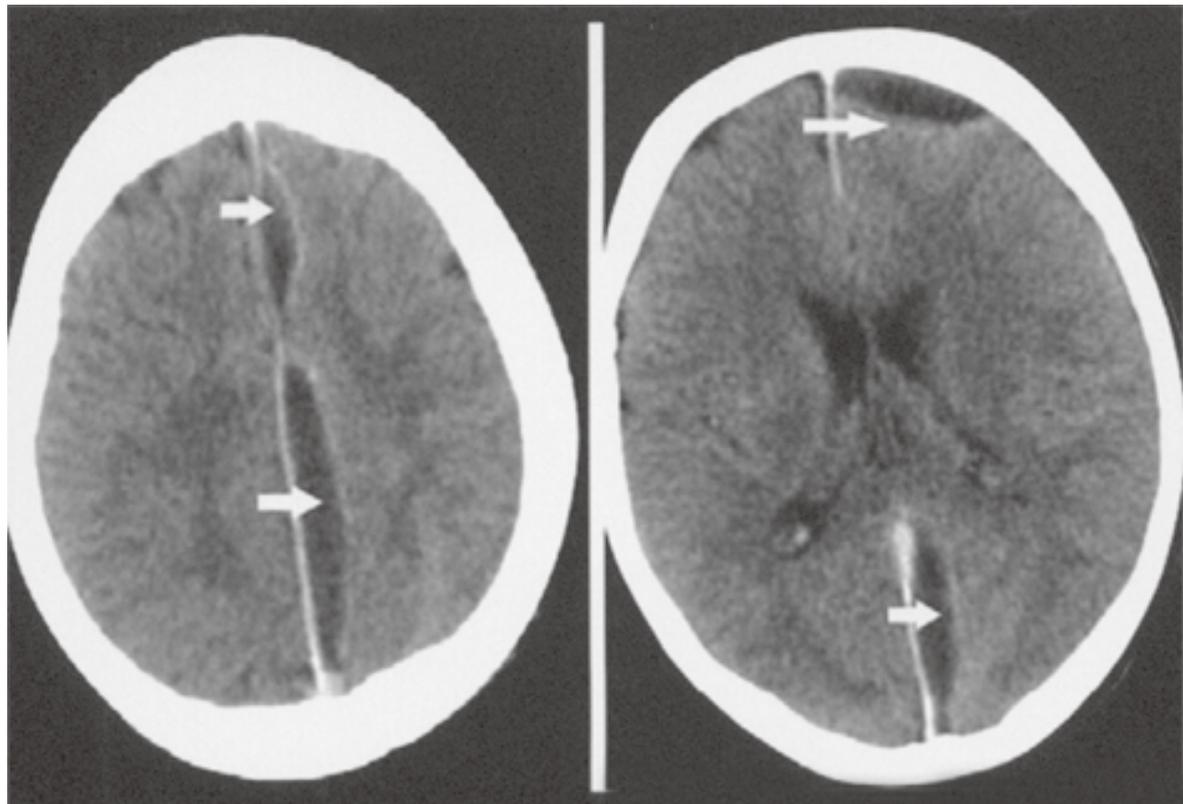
Contrast-enhanced axial CT image shows multiple interhemispheric and left frontal subdural empyemas (arrows).
